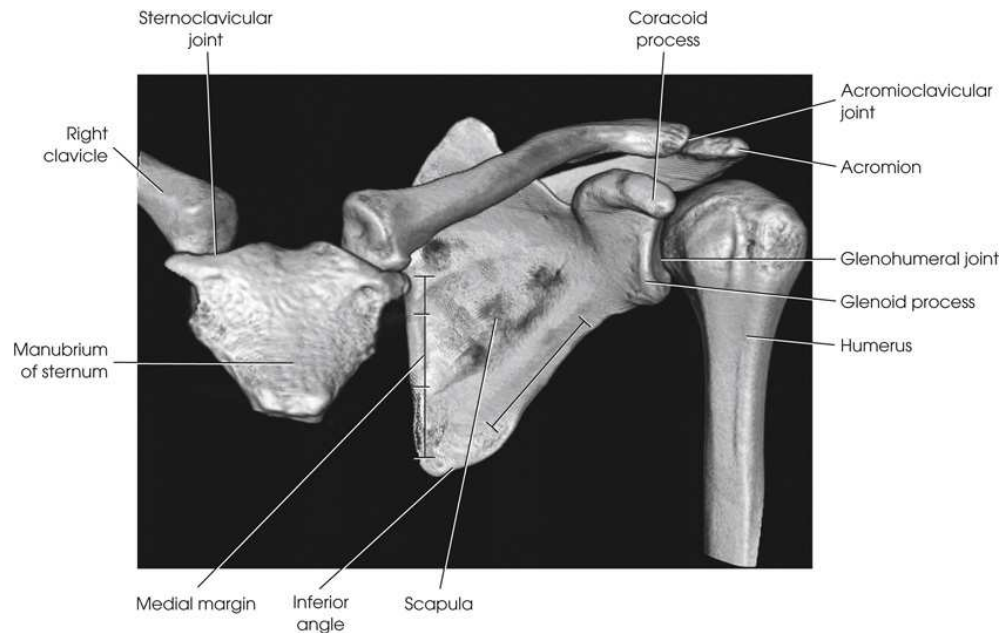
Three-dimensional CT image of shoulder girdle. Note three articulations.
